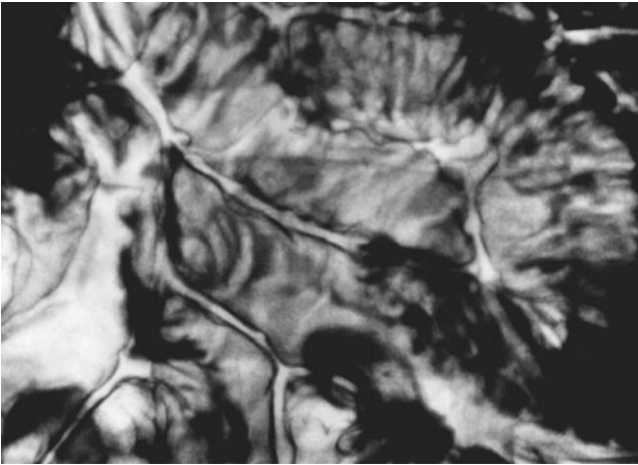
Small intestinal radiography of a different case. Multiple aphthae were evident
